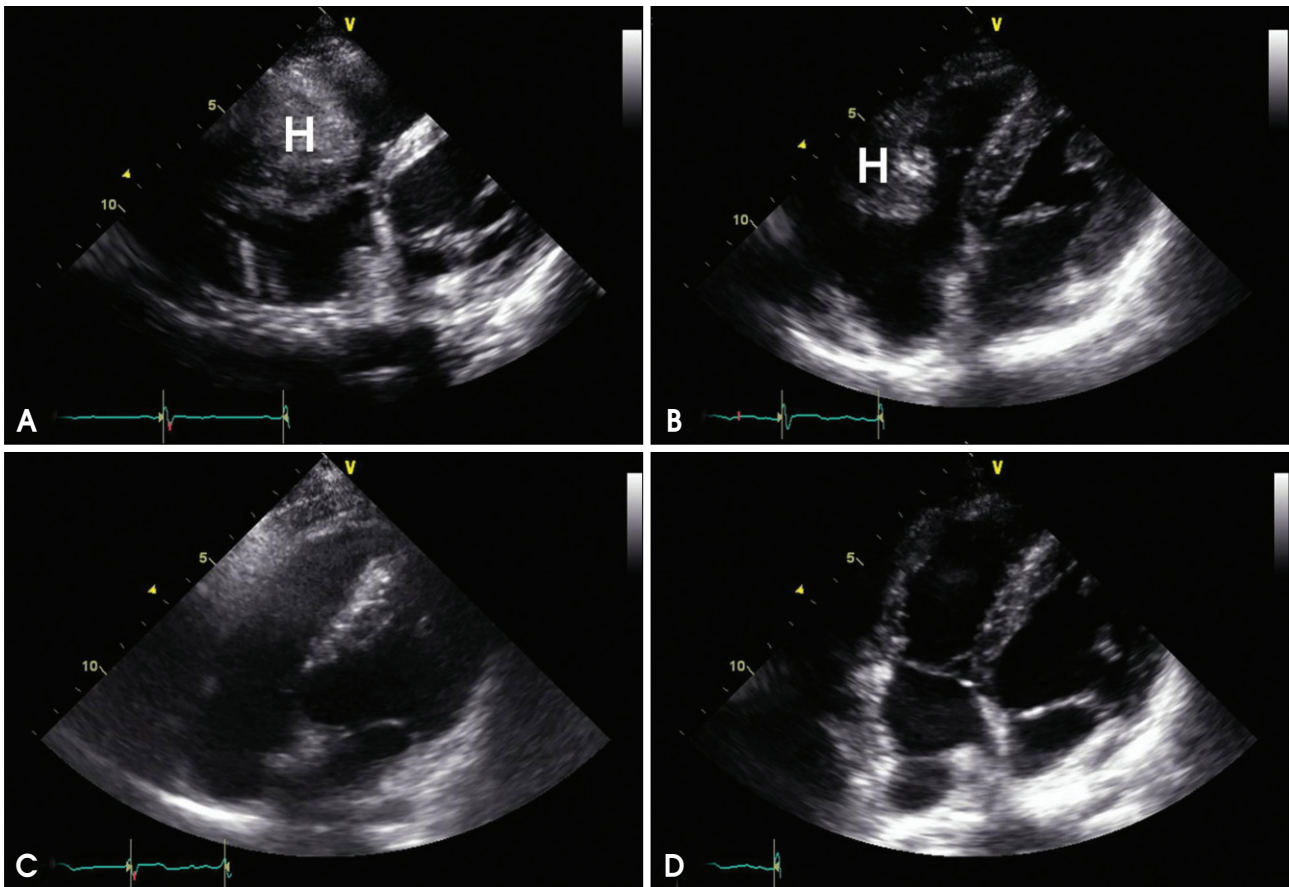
Serial two-dimensional echocardiography images. Comparing with preoperative status (A), postoperative echocardiography (B) showed that a substantial volume of hematoma (H, hematoma) still remained. However, the 6th (C) and 12th (D) -month follow-up echocardiography showed complete resolution and no recurrence of the hematoma.
